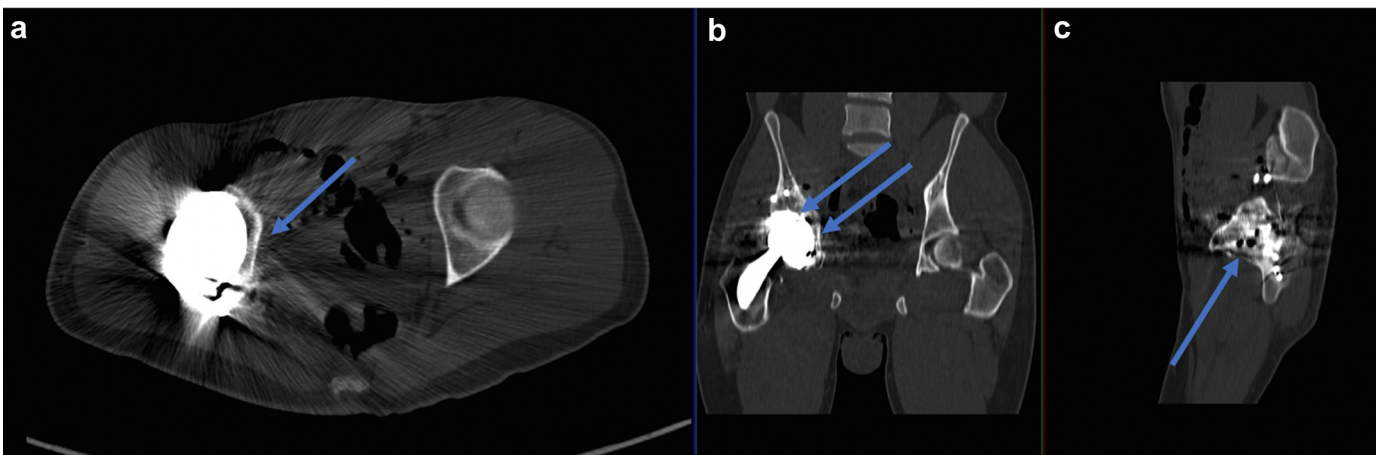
Computed tomography images (a; axial, b; coronal, and c; sagittal) at 1 year postoperatively demonstrating hip reconstruction with resolution of protrusion, stable fixation of acetabular fixation, and osseointegration of the acetabular shell as indicated by the blue arrows. There is no evidence of local tumor recurrence.
